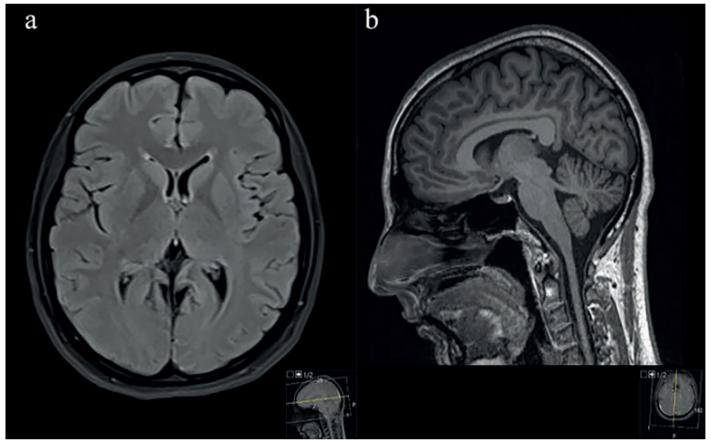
Axial T2 FLAIR (a), sagittal T1 MPRAGE (Magnetisation Prepared Rapid Acquisition Gradient Echo) (b) volumetric images.
